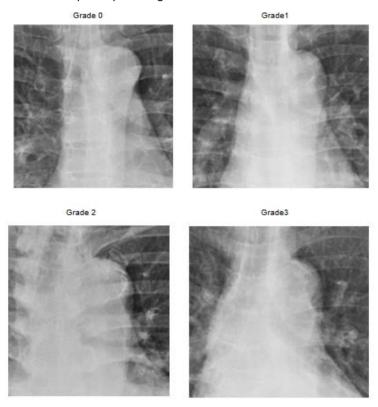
Assessment of aortic arch calcification from chest radiograph (Woo et al., 2016)
